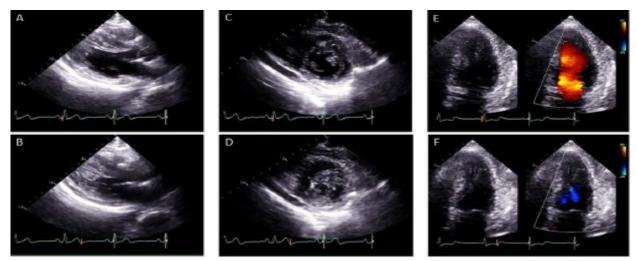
Transthoracic Echocardiography: Parasternal long axis views show myocardial hypertrophy in the intraventricular septum at end-diastole (A), along with mid-ventricular obstruction at end-systole (B). Myocardial hypertrophy and mid ventricular obstruction of the left ventricle are also observed in short axis images at end-diastole (C) and end-systole (D), and in four-chamber apical views with color Doppler at end-diastole (E) and end-systole (F).
